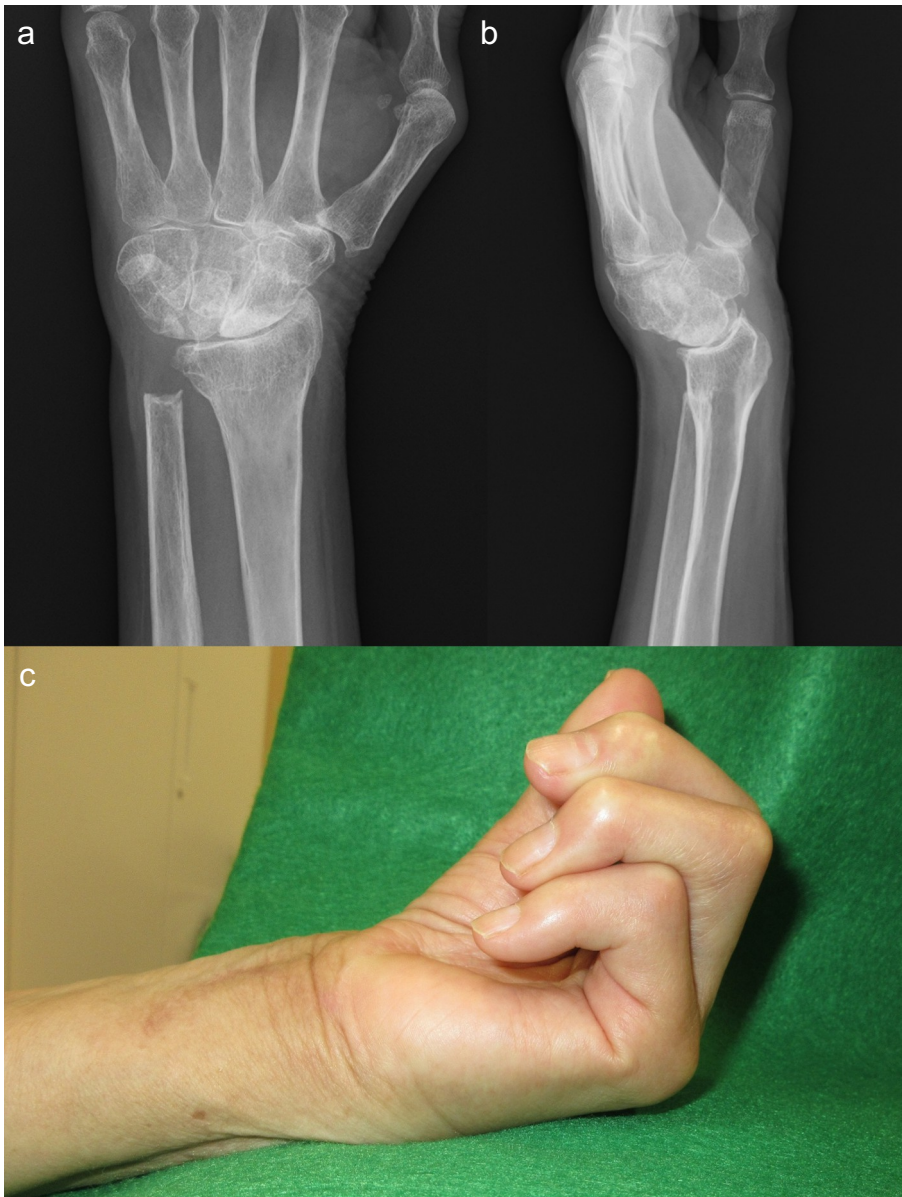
a and b Postoperative posteroanterior and lateral view radiographs of the left wrist of the Case 2 at 5 months follow-up after Darrach procedure. c Macropicture of the Case 2 after tendon reconstruction at 5 months follow-up.
